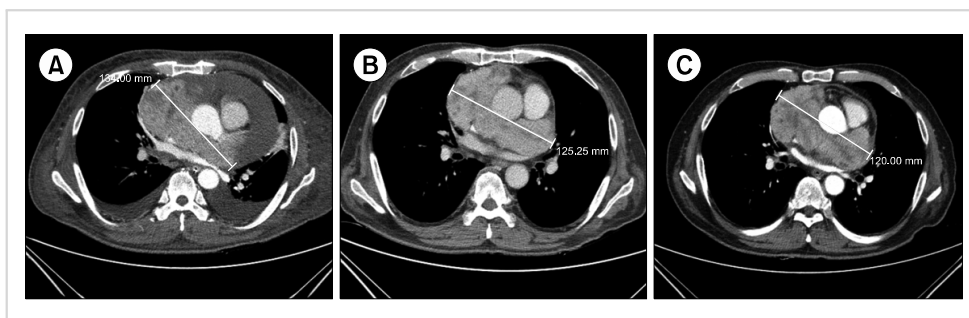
Chest computed tomography (A) at diagnosis, (B) after three cycles of CAP, and (C) six months after completion of chemotherapy.
